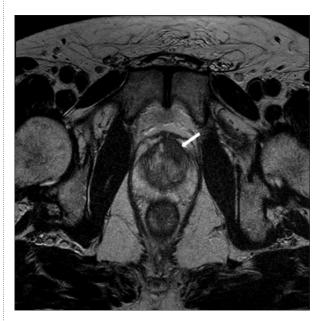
T2-weighted MRI – Reduced signal in the anterior gland predominantly on the left involving the anterior capsule but no evidence of extracapsular disease (arrow).
